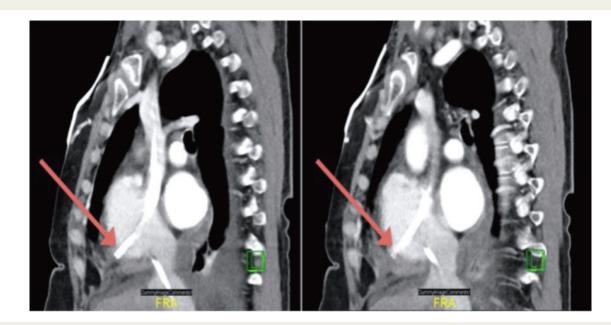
Repeated computed tomography of the thorax raising suspicion for a migration of the tunnelled cuffed haemodialysis catheter through the right atrial wall (indicated by red arrows).
